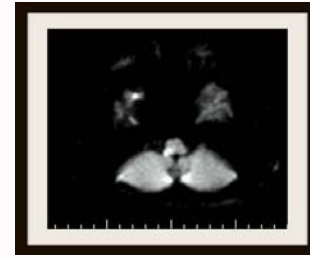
MRI of the brain identified an area of restricted diffusion in the right lateral medulla.
